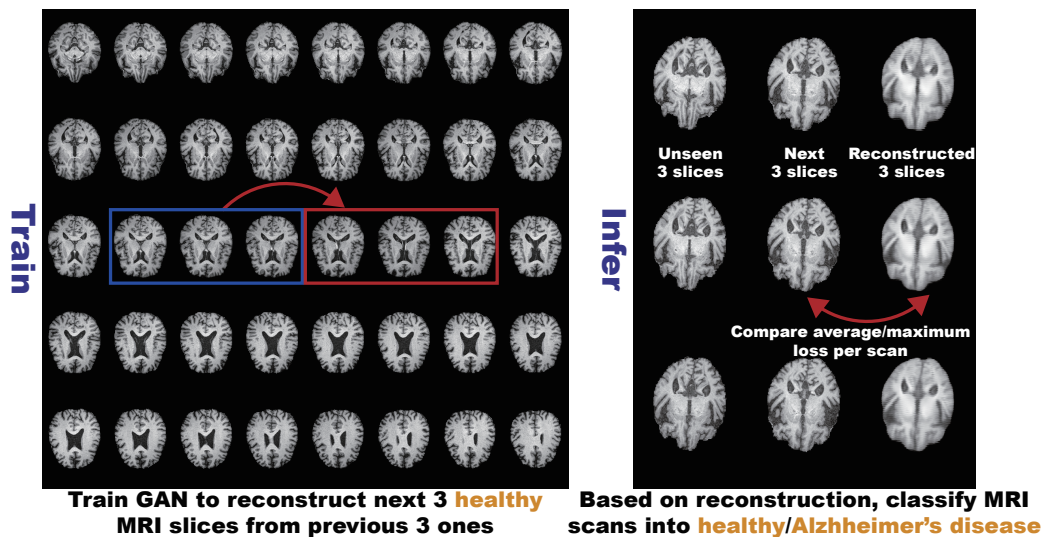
Unsupervised AD diagnosis framework: We train WGAN-GP +  $\ell_1$  loss on 3 healthy brain axial MRI slices to reconstruct the next 3 ones, and test it on both unseen healthy and AD cases to classify them based on average/maximum loss (e.g.,  $\ell_2$  loss) per scan.
